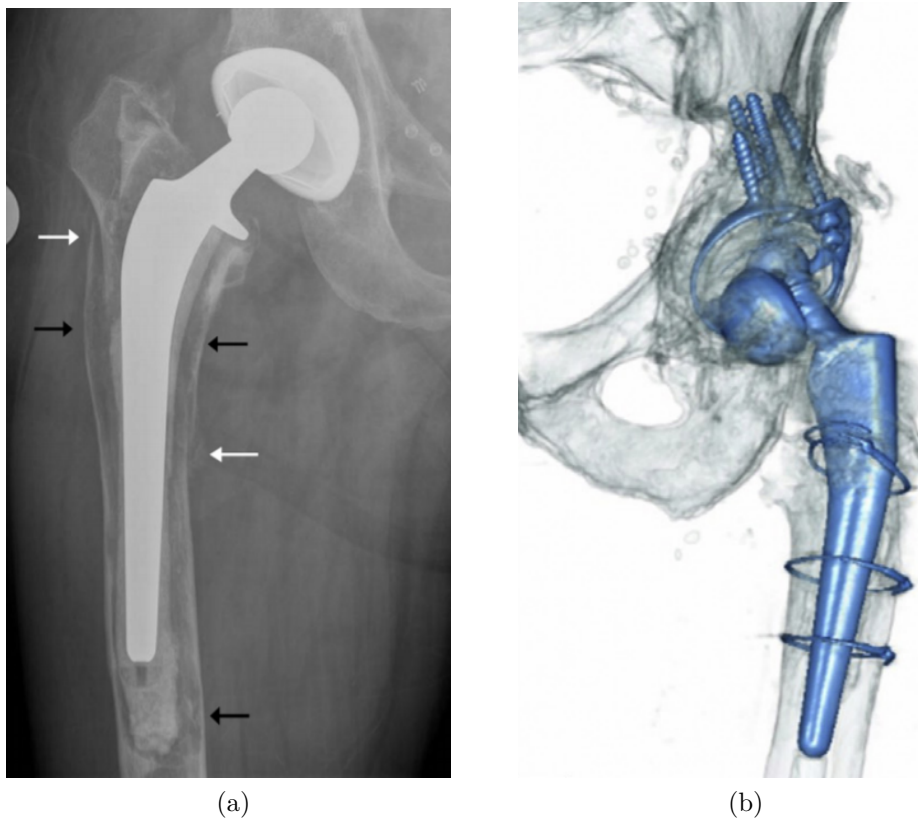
(a) Radiography showing radiolucencies which may be indicative of mechanical loosening in the cement-bone interface [20]. (b) CT scan of a hip implant showing the resulting three-dimensional image [19].
